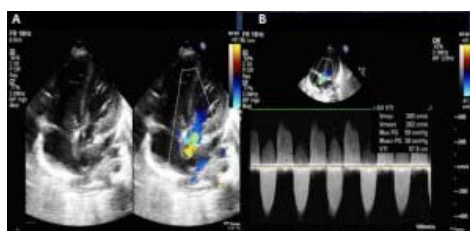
A) Transthoracic 2D ECHO with Apical 5 chamber showing restricted aortic valve opening and turbulence across the aortic valve. B) Continuous wave Doppler showing a mean gradient of 36mm Hg across the aortic valve
